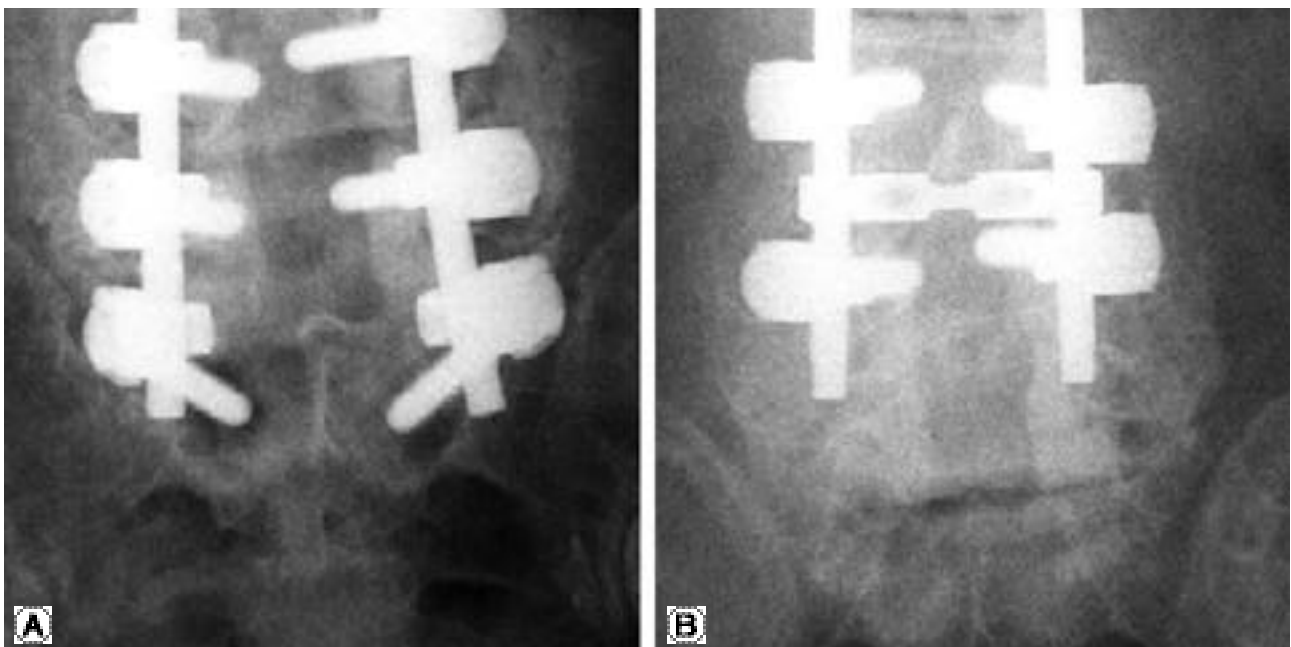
(A) Wide radiolucent zones around the both sacral screws. (B) Radiograph after removal of sacral pedicle screws, which had shown severe loosening in the operating field.
